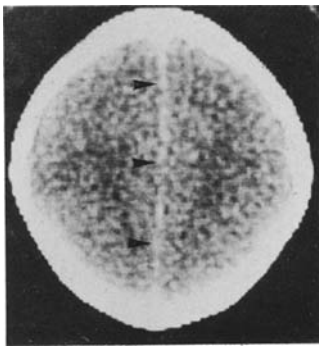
Interhemispheric subarachnoid hemorrhage (falx sign) in a 5-year-old girl who became unconscious immediately after being struck by an automobile. CT scan without contrast material shows a thin stripe of blood density between the cerebral hemispheres (arrowheads).
